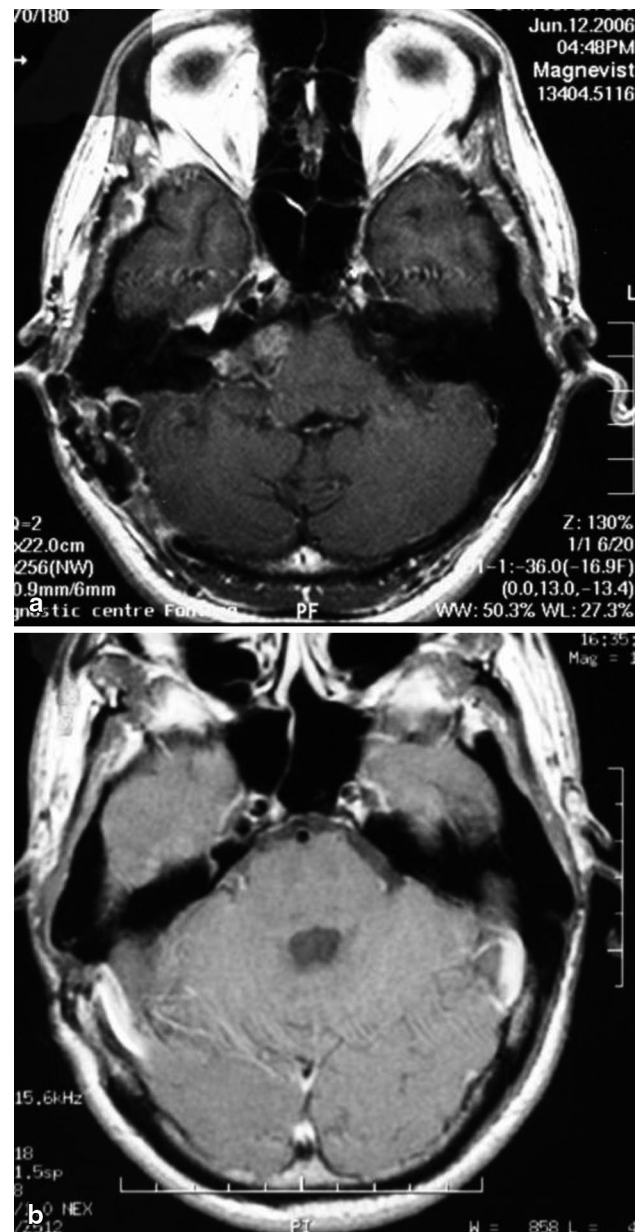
A tumour residue in the right pontocerebellar angle after non-radical resection on axial magnetic resonance imaging scan (a). After the gamma knife treatment, the residue shrank significantly (b)
